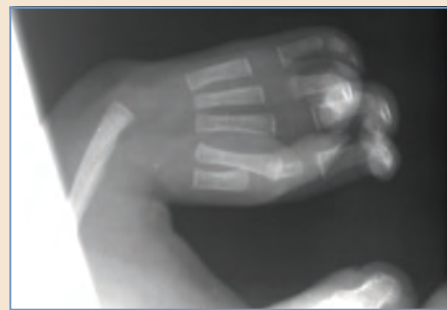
Radiograph of a 10-month-old patient with total absence of the radius. The thumb is present.
